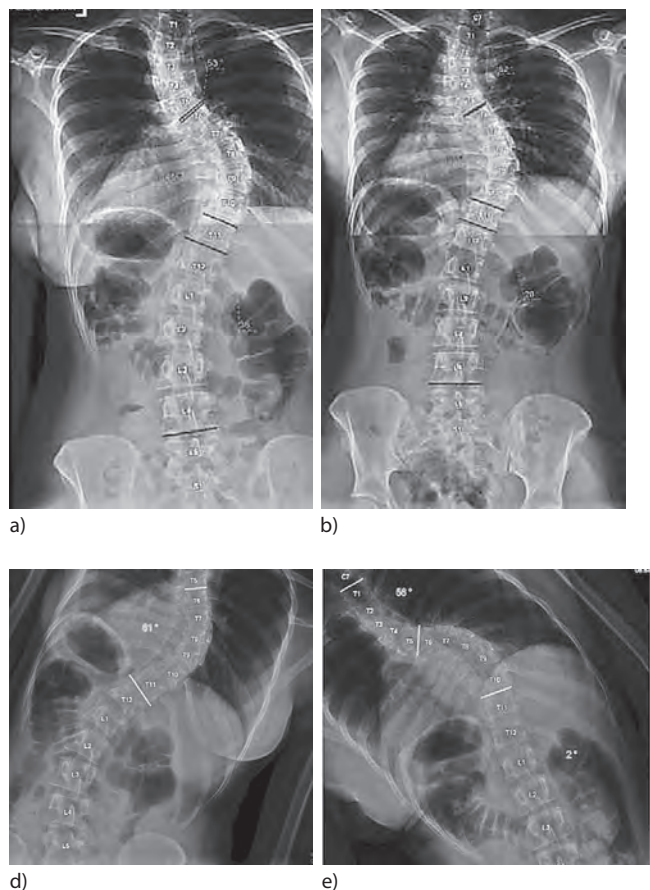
The Cobb angle measurement on: a) standing PA, b) supine traction, c,d) both side bending on postero – anterior radiographs
